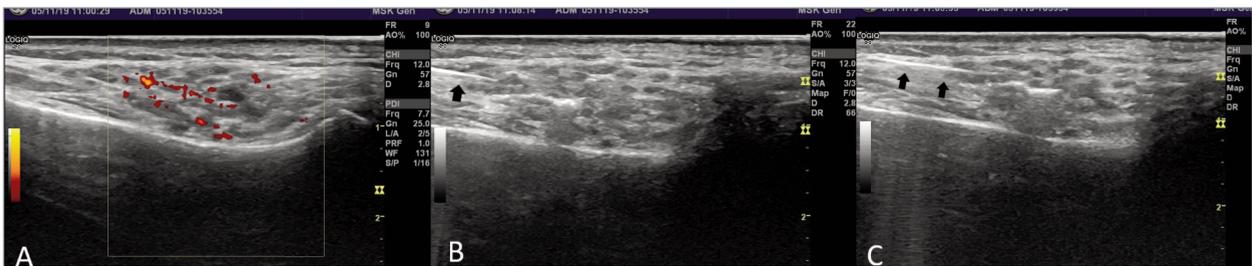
USCB of the parotid gland. A) Longitudinal ultrasound image of the parotid gland with power Doppler showing inhomogeneity with multiple hypochoic areas. B and C) Ultrasound images with the biopsy needle in the parotid gland (black arrows).
